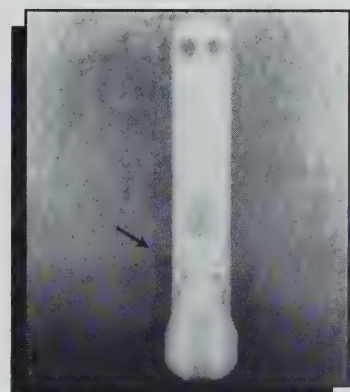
Radiograph of bony defect, as seen in Figs. 5 & 6. Surgical intervention using regenerative techniques, 12-months post-surgical intervention.
